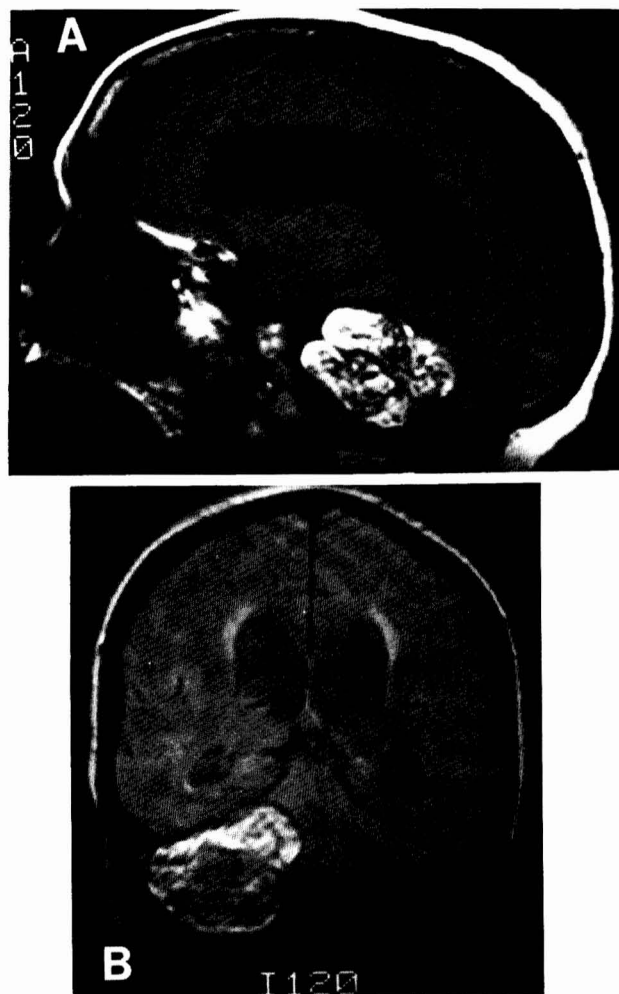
Case 3. A, T1-weighted sagittal MRI scan showing a range of signal intensity in the tumor. B, T2-weighted coronal MRI scan.
